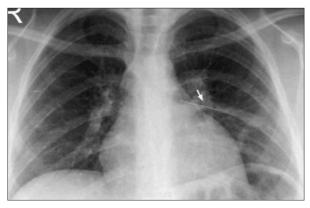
Posteroanterior chest radiograph showing hatpin (arrow) lodged in left upper lobe bronchus (case 2).
